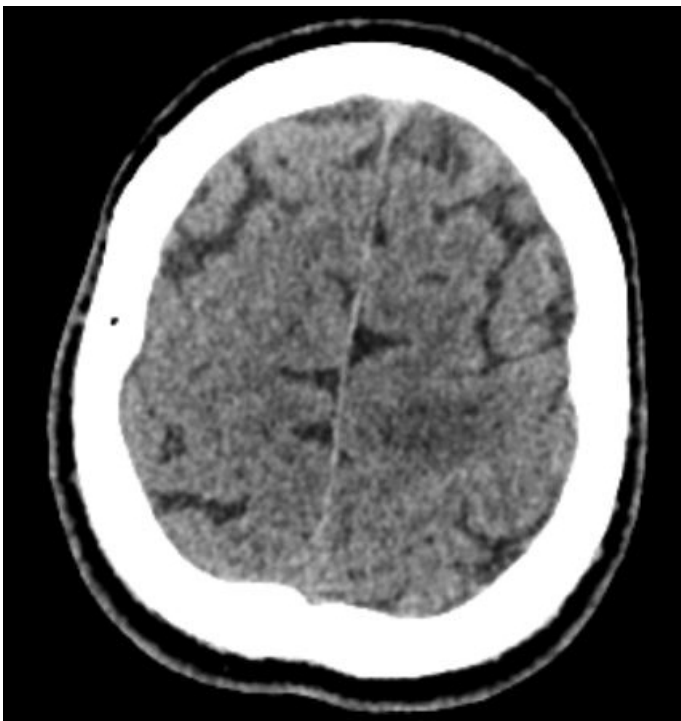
No hemorrhage on the control computed tomography taken at the 24<sup>th</sup> h.
